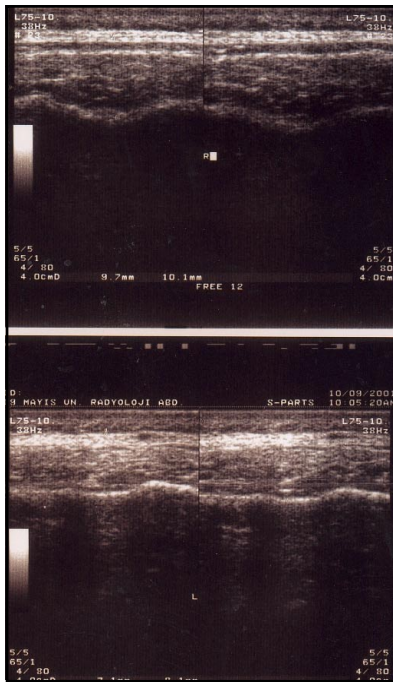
Ultrasonographic image of the thickness (mm) of masseter muscle in both relaxed and contracted conditions in experimental group.
